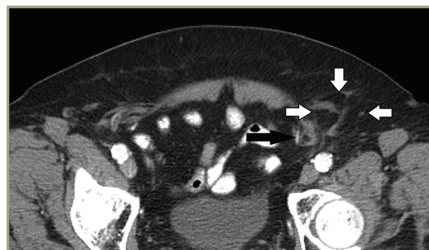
CT of indirect inguinal hernia (white arrows) located lateral to the inferior epigastric vessels (black arrows).
